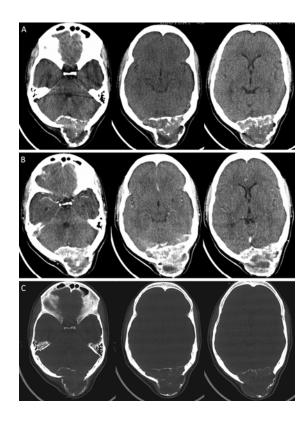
Plain axial CT scan images. A: Mixed-density, expansile and lytic lesion of the occipital bone; B: irregularly enhanced lesion after contrast administration; C: extensive destruction of the occipital bone with a poorly defined, coarse trabecular pattern and irregular border.
